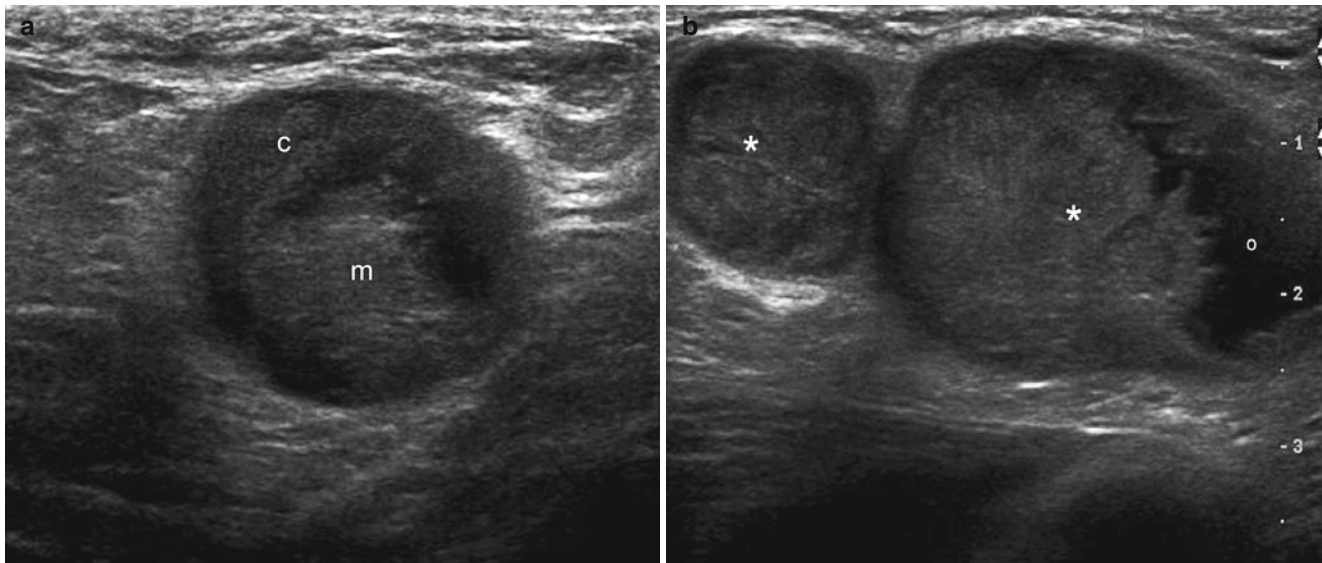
(a, b) Metastatic lymph nodes (melanoma). (a) Grey scale ultrasound image (transverse view, right axilla) demonstrates a well-defined round-shaped subcutaneous nodule that presents a thick hyperechoic cortex (c) and a slightly hyperechoic medulla (m). (b) Grey
